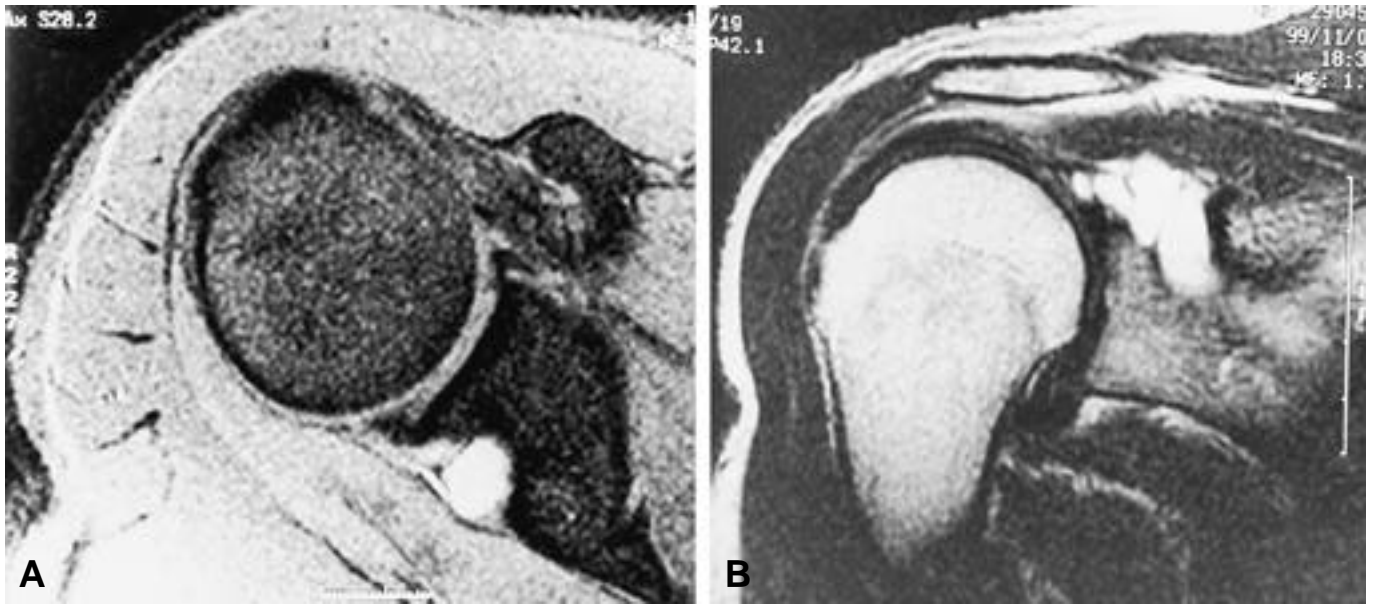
MRI scan showed multilobulated ganglionic cyst extended from the right suprascapular notch to scapular spinous level with high signal intensity in the axial(A) and coronal(B) T2-weighted images.
